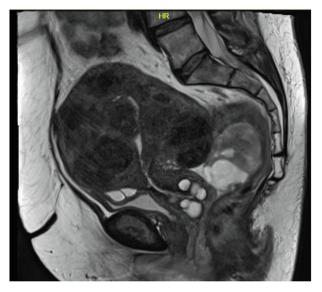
a: MRI: T2 Sagittal Pelvis. b: MRI T2 Axial Pelvis.
